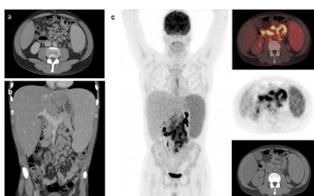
Axial (a) and coronal (b) abdominal CT images presented hepatosplenomegaly and innumerable mesenteric and retroperitoneal adenopathies. ^{18}F -FDG PET/CT (c) showed hypermetabolic mesenteric and retroperitoneal lymph nodes, bone marrow and splenomegaly metabolically positive as well as normometabolic hepatomegaly. Increase uptake of FDG in the distal esophagus secondary an esophageal candidiasis demonstrated by biopsy.
